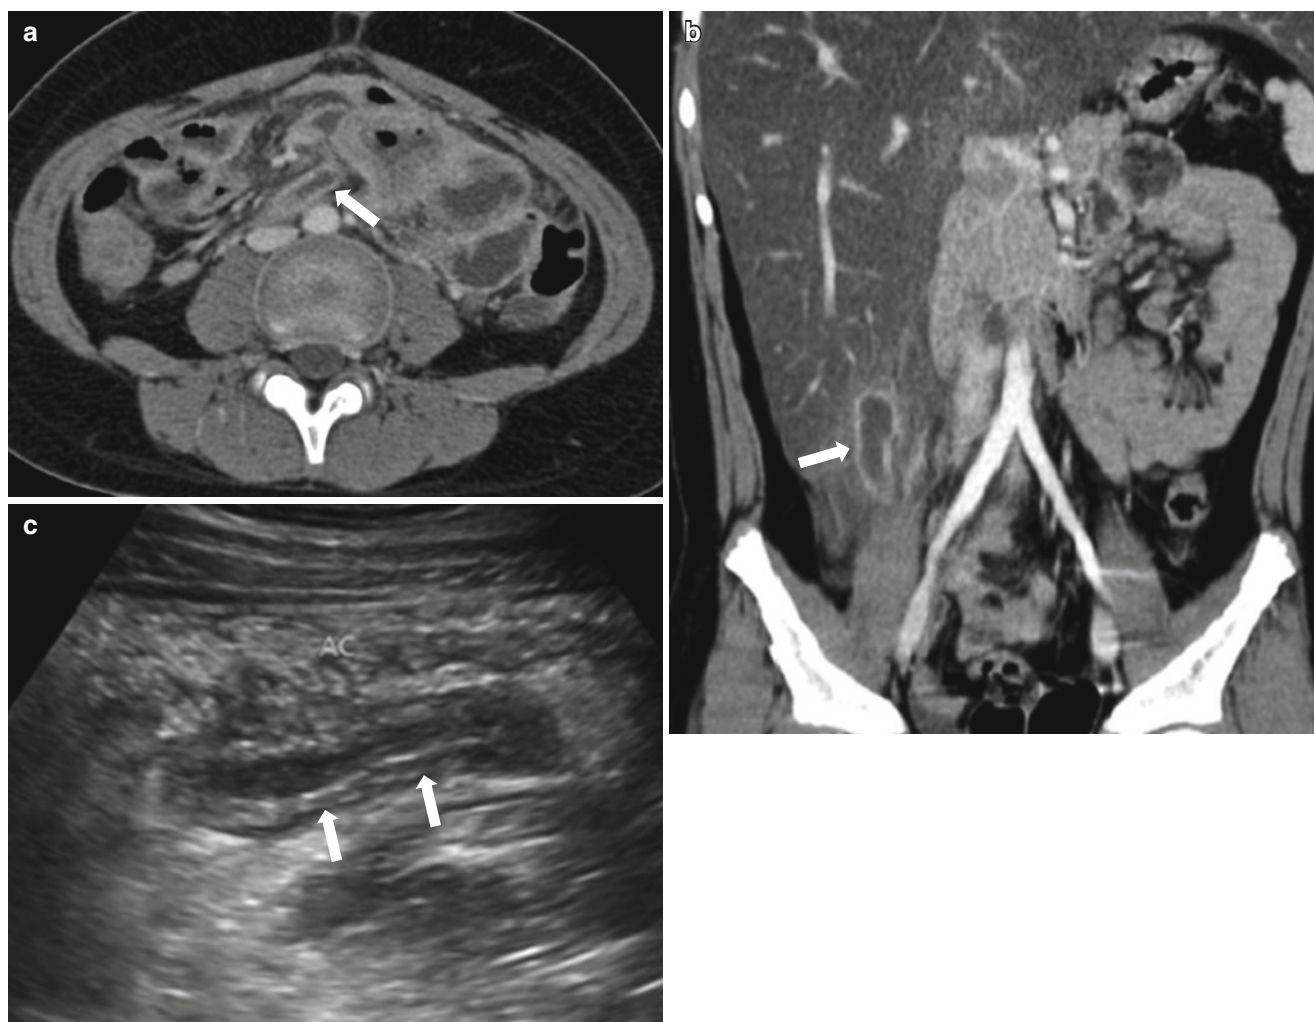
Variable location of appendix: pitfall in diagnosing appendicitis. (a, b) CT images in two different children with acute appendicitis show anatomical variation of appendix (*arrow*), which is midline in (a) and subhepatic in (b). (c) In another 12-year-old girl who presented
